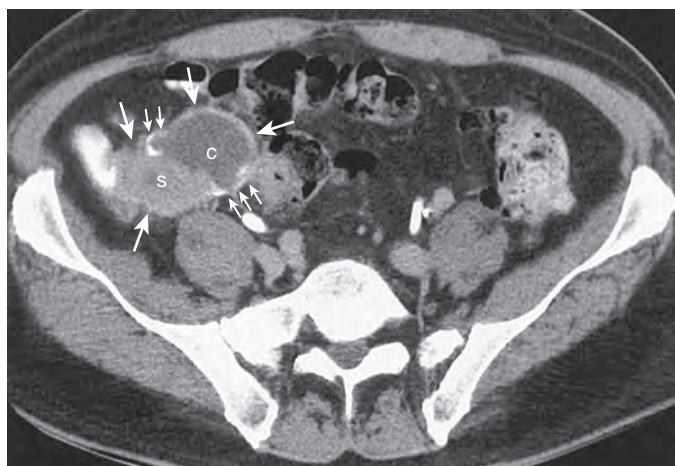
Mucinous cystadenocarcinoma of the appendix. CT detects a mass having solid (s) and cystic (c) components in the right pelvis inferior and medial to the cecum (large arrows). Peripheral calcifications are seen in the cystic component (small arrows).
